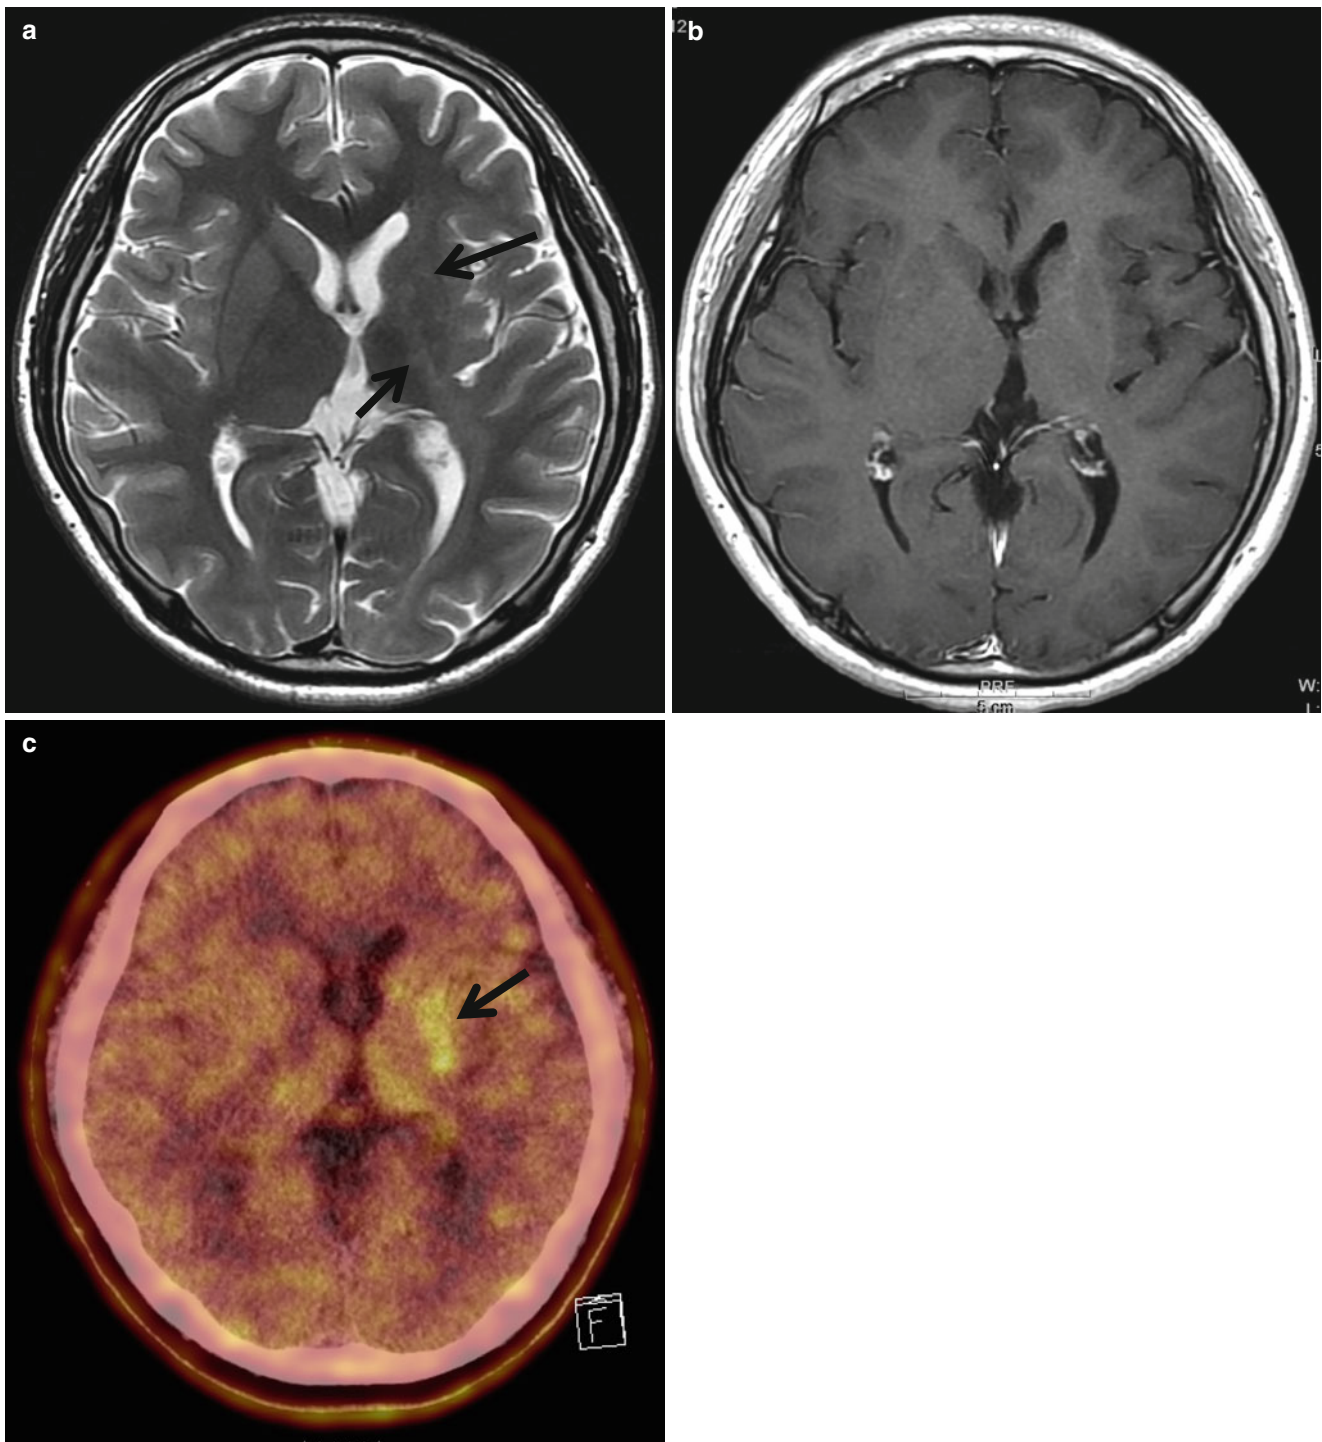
Basal ganglia germinoma in a 14-year-old girl. (a) T2-weighted image shows subtle high-intensity lesion involving left internal capsule and basal ganglia (*arrow*), associated with ipsilateral atrophy of the basal ganglia and thalamus. (b) Postcontrast image
